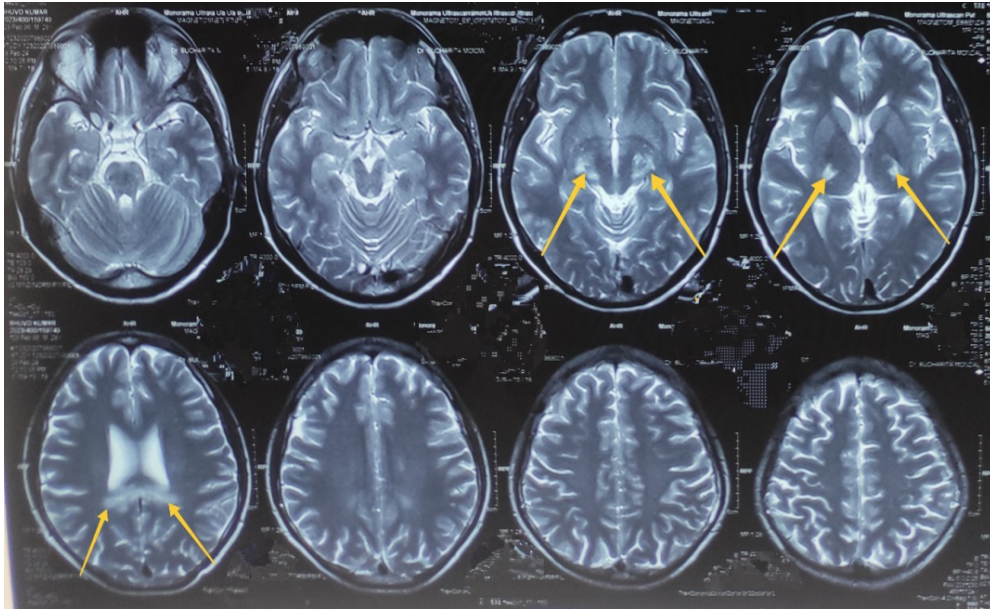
MRI of the brain, T2-weighted axial images showing symmetric hyperintensities in the white matter tracts of brain (yellow arrow).
